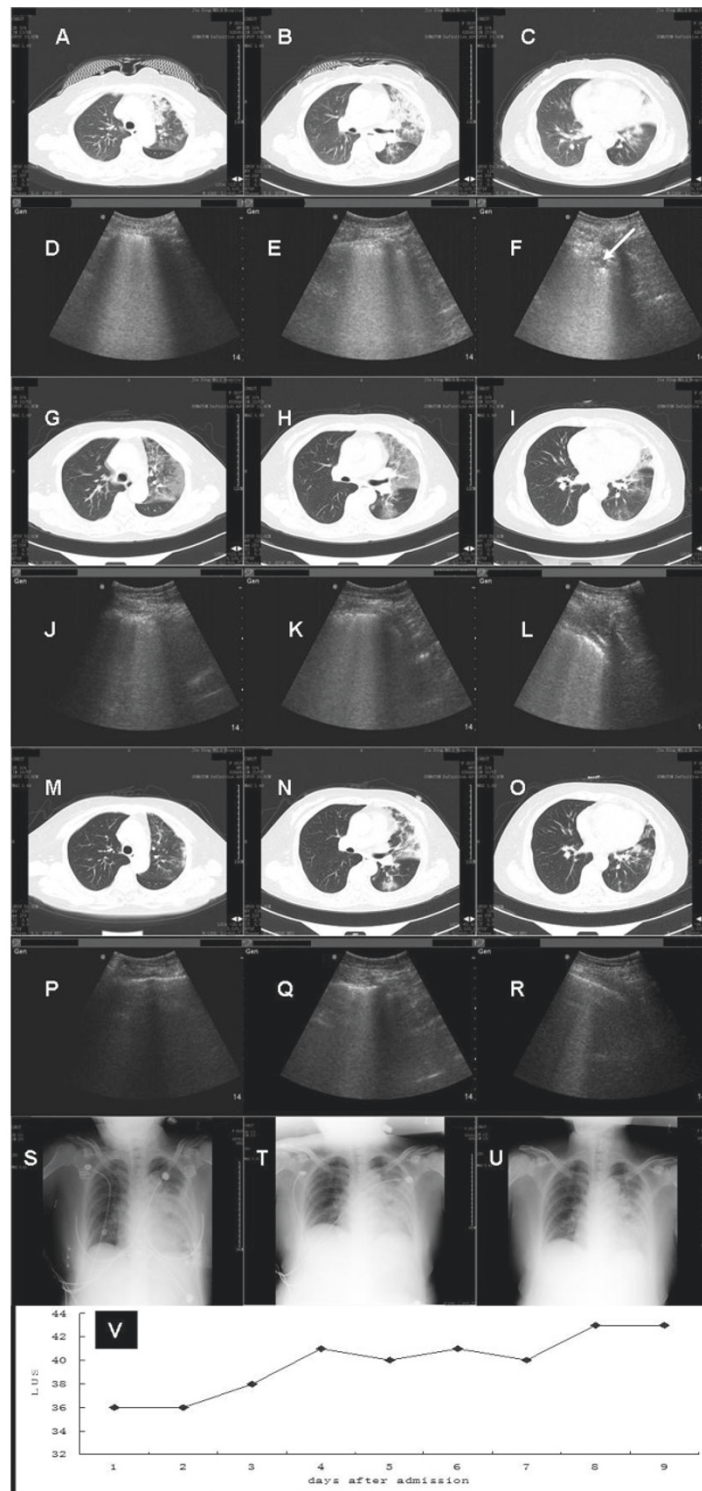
Dynamic changes of chest computed tomography (CT), radiography, and lung ultrasound in a patient with H7N9 influenza. (A-C) CT showed pneumonia in the left upper lung, with partial consolidation on admission. (D-F) Lung ultrasound corresponding to CT in (A-C) showed multiple abutting B2 lines, and some regions presented a tissue pattern (arrow). (G-I) CT on day 6 after admission showed that the pneumonia was partially absorbed. (J-L) Lung ultrasound corresponding to CT in (G-I) showed that the number of B lines was obviously decreased, and the consolidation disappeared. (M-O) CT on day 9 after admission showed that the size of the lesion was obviously reduced. (P-R) Lung ultrasound corresponding to CT in (M-O) indicated that only the A line and few B lines were visible. (S-U) Chest radiography on days 1, 3, and 6 after admission showed no obvious change of the pneumonia. (V) Dynamic changes of lung ultrasound score (LUS) (total of 48 for normal lung).
